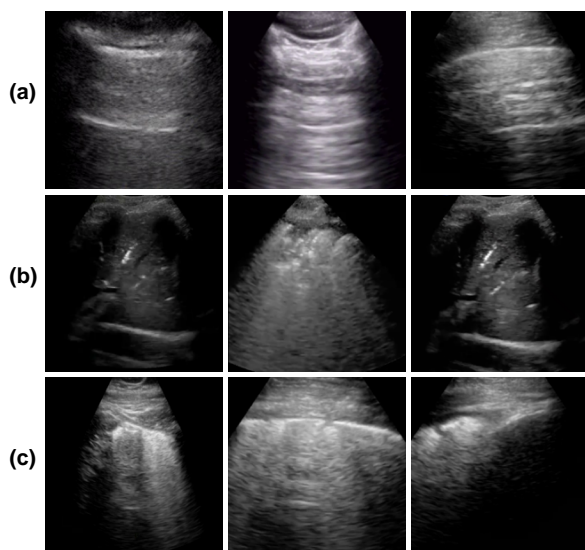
Example lung ultrasound images utilized in this work representing classes (row-wise) of (a) Healthy lung, (b) Pneumonia infected lung, and (c) Lung infected with COVID-19 exhibiting pleural irregularities and small subpleural consolidation.
